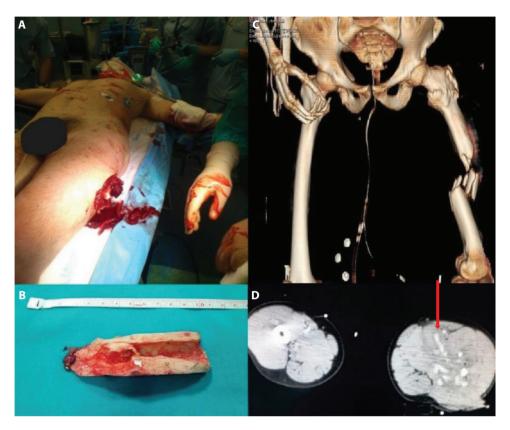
Clinical image showing open femoral fracture with femoral artery lesion (A). 10 cm avulsed femoral bone fragment on the street (B). 3D reconstruction of a total body CT scan showing a complex femoral fracture (C). Axial image of a contrast-enhanced CT scan showing femoral artery lesion of the left thigh (red arrow) (D).
